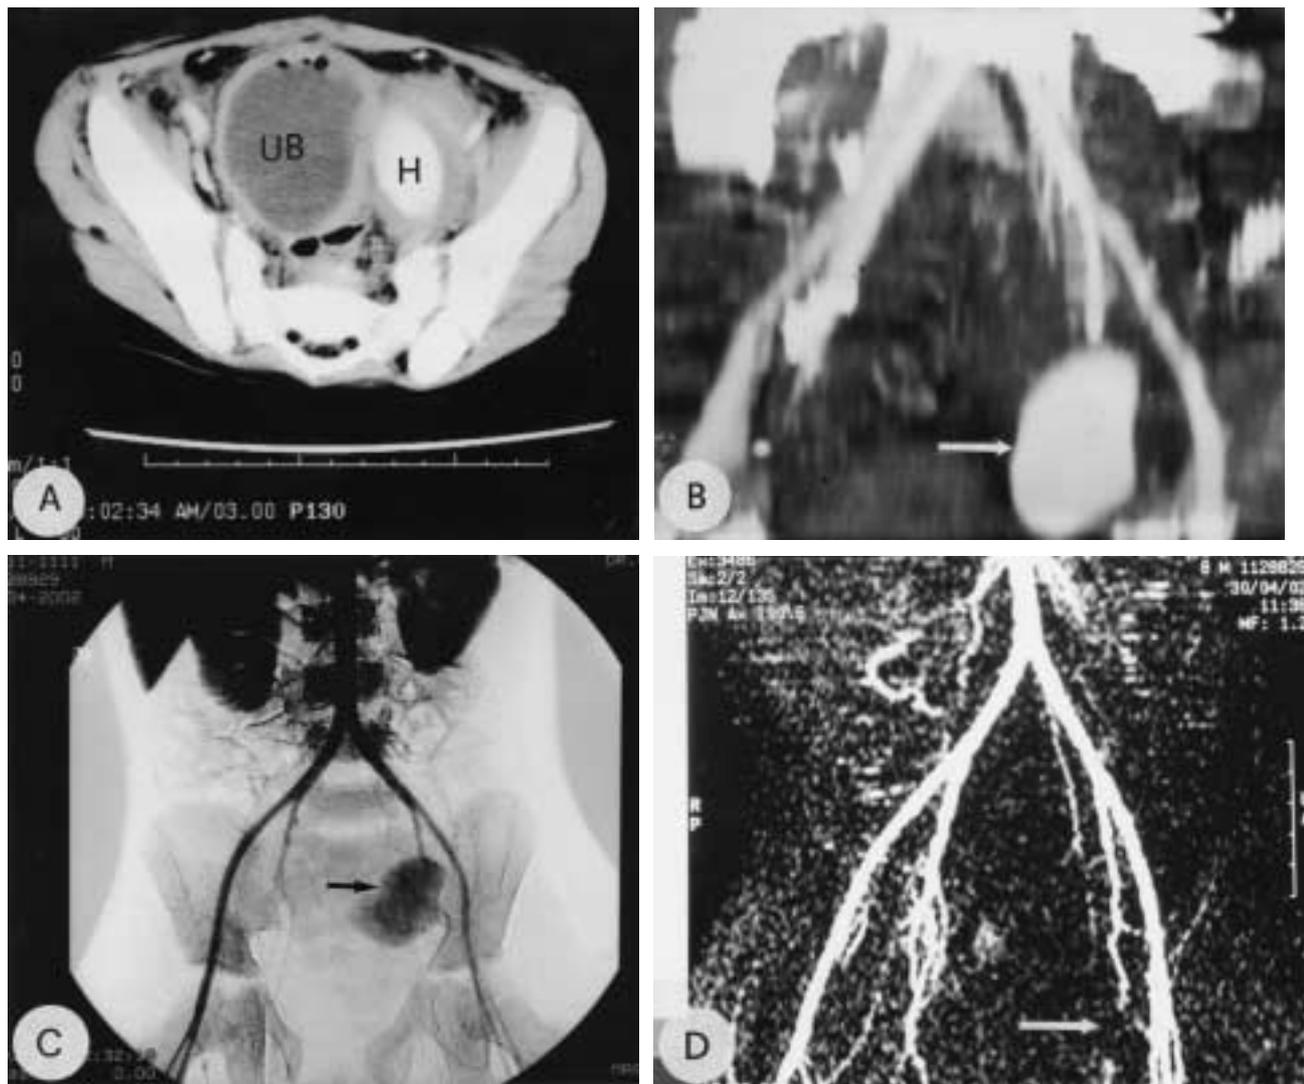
A: CT scan of the pelvis (transverse cut) showing pelvic hematoma (H) in the left side, pushing the distended urinary bladder (UB) to the right. Note the clot inside the hematoma cavity (whitish).
